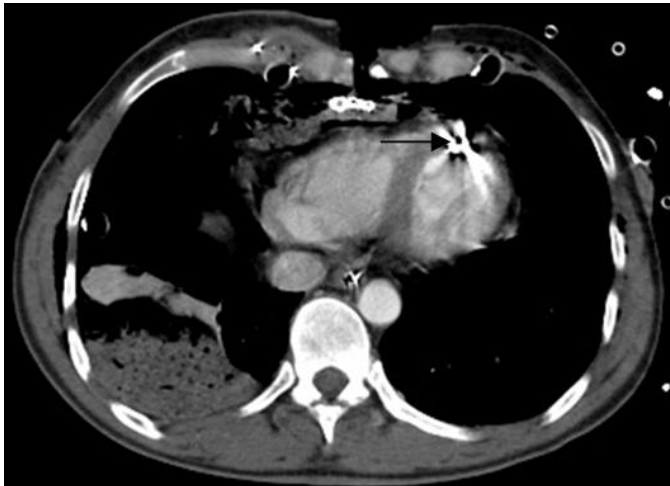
Contrast enhanced CT of the chest demonstrates a bullet within the left ventricle at risk for arterial embolization.
